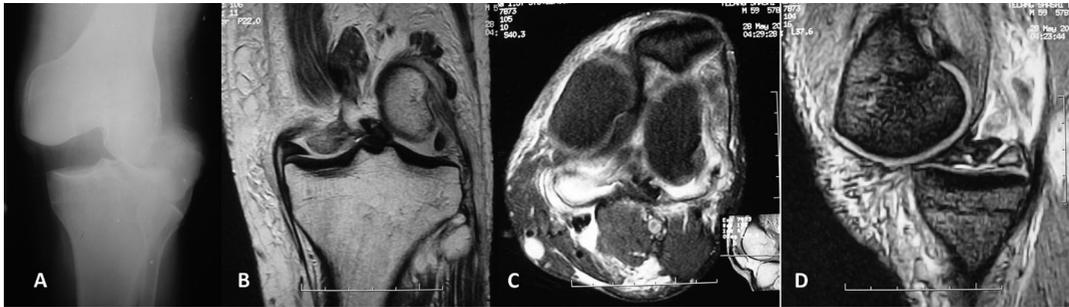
Irreducible knee dislocation. (a) Prereduction AP radiograph reveals a posterolateral knee dislocation. (b–d) MRI reveals a complex knee dislocation in which
